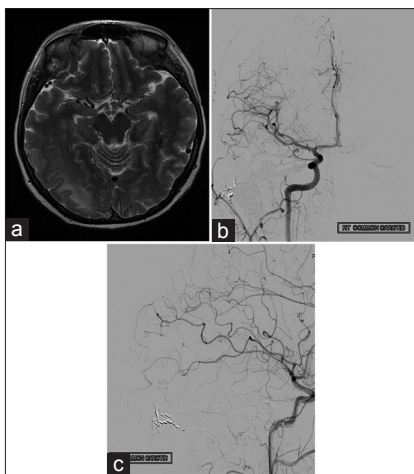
(a) Magnetic resonance imaging (T2-weighted). Three-month postembolization showing a significant reduction in venous congestion. (b) Angiogram. Two-year postembolization image demonstrating no evidence of residual dural arteriovenous fistula. (c) Angiogram (lateral). Two-year postembolization image demonstrating no evidence of residual dural arteriovenous fistula
